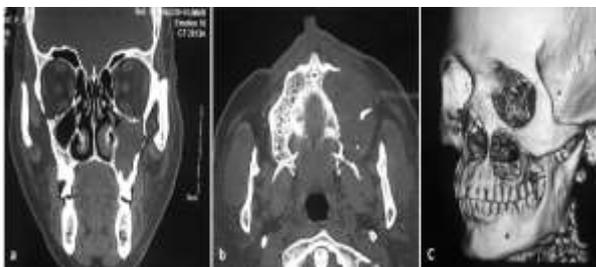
Computed Tomography showing an osteolytic lesion involving entire maxillary sinus (a), with resorption of anterior wall of maxilla (b), formatted 3D image of lesion
